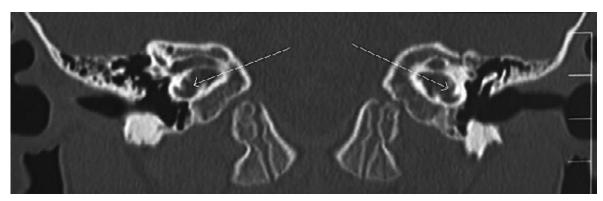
Coronal CT image of the temporal bones.
